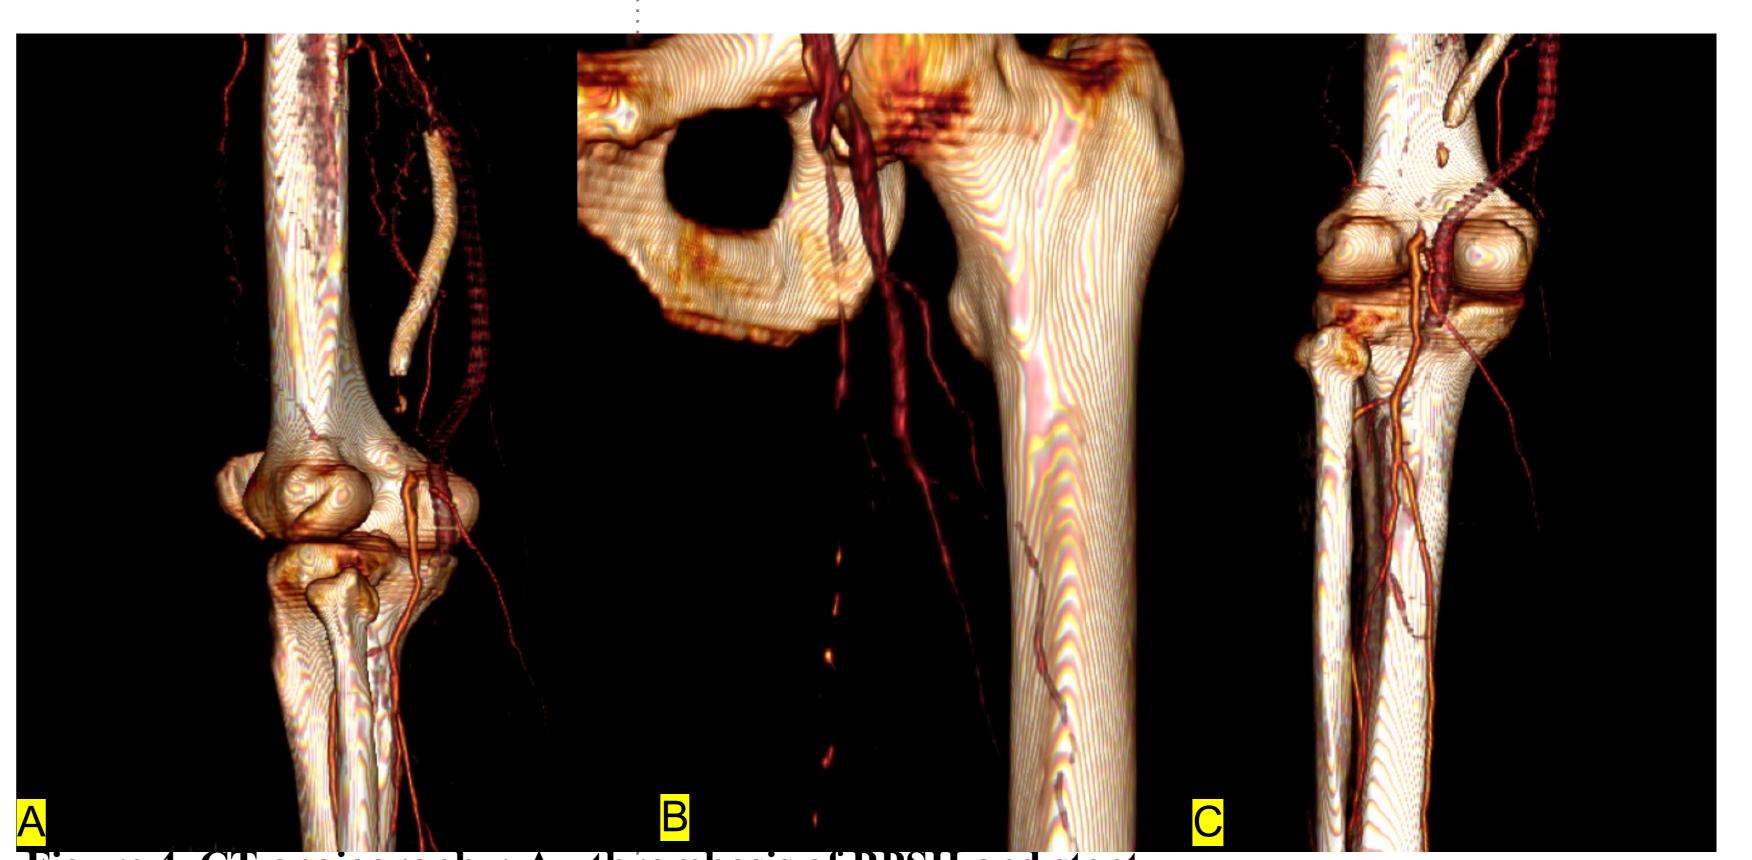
CT angiography: A - thrombosis of BPSH and stent. B - Stenosis of DFA on the left. C-inadequate arterial distal bed.
